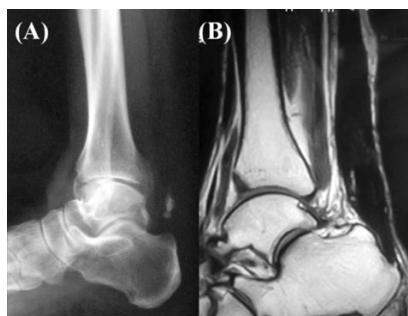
(A) Lateral radiograph demonstrating a negative Kager's sign. There is no abnormality in the bone and joint construction. (B) Magnetic resonance image showing a common tear of the Achilles tendon.
